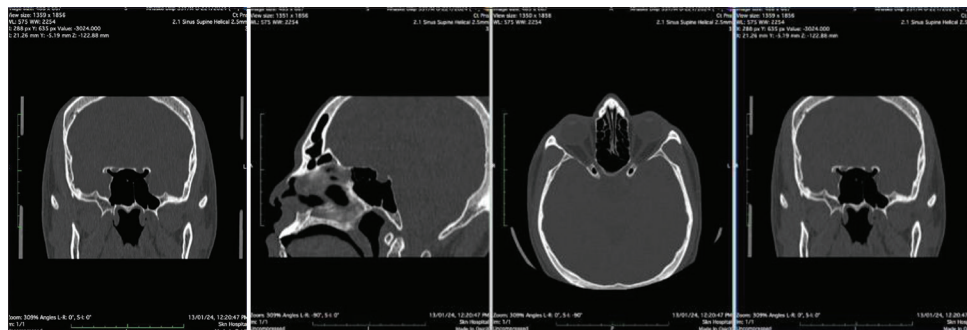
Onodi cell (right superolateral to sphenoid sinus) is best visualized in the coronal plane on CT
